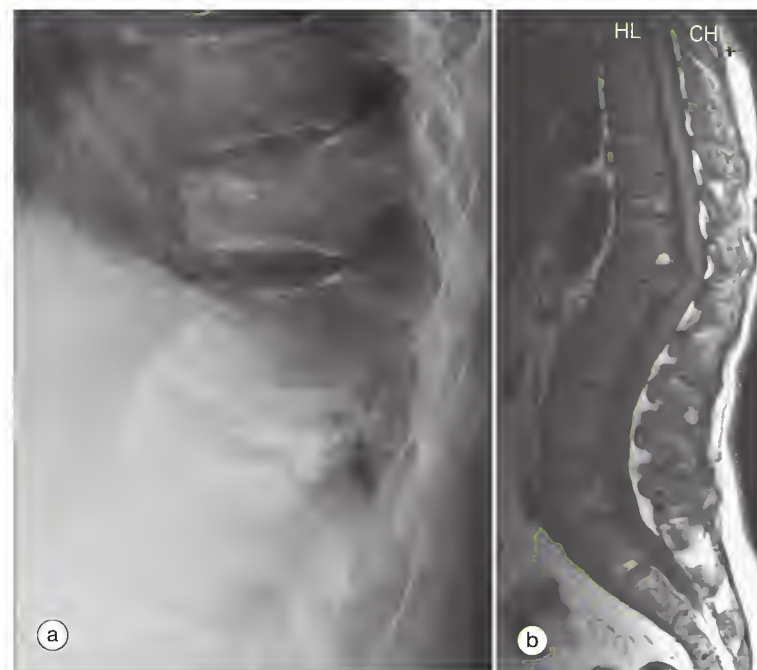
(a) Severe compression fracture of the T12 vertebra with subsequent hyperkyphosis. The T10 vertebra is also crushed and has a grade 2 fracture. (b) In the same patient, magnetic resonance imaging of the spine shows spinal cord compression and angulation, although the patient remained free of neurologic complications, and diffuse heterogeneous low-intensity signal of all vertebrae on this T1-weighted sequence.
